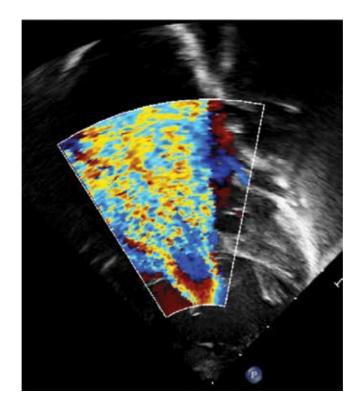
Apical 4 chamber with color flow imaging of the tricuspid valve. There is severe tricuspid valve regurgitation due to poor coaptation of the tricuspid valve leaflets.
